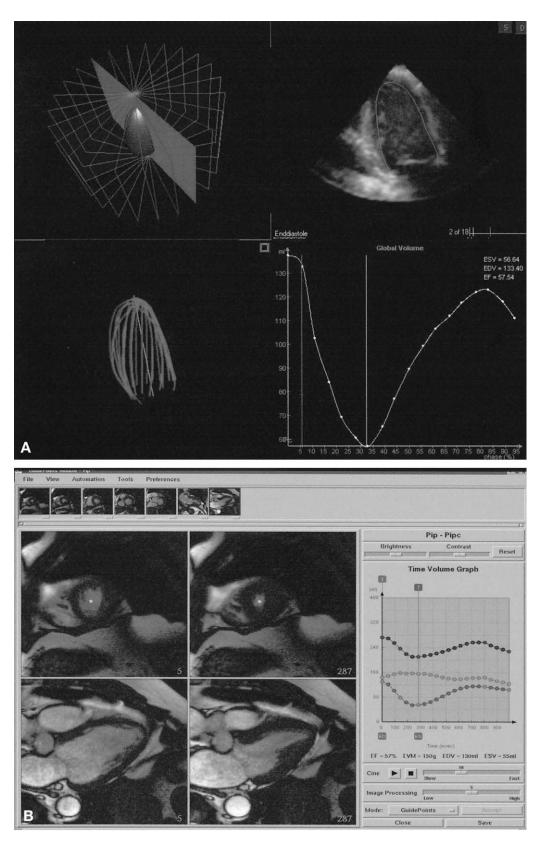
(A) Analysis of left ventricular (LV) volume using three-dimensional echocardiography. The figure demonstrates selection of one image (upper right), automated contour-tracing (upper left), superimposition of all contours in three-dimensional space (lower left), and the resulting time-volume curve (lower right). (B) Analysis of LV volume using magnetic resonance imaging. The position of apex and base is shown on the longitudinal plane images, and endocardial and epicardial borders are traced in the short-axis views. EDV = end-diastolic volume; EF = ejection fraction; ESV = end-systolic volume; LVM = left ventricular mass.
